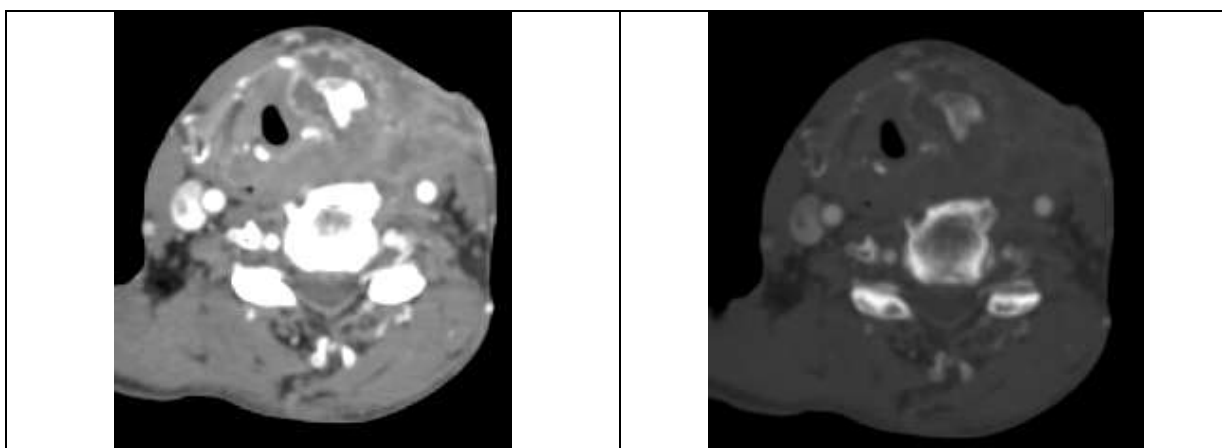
(a) and 7(b): Axial CECT and CT bone images at the level of thyroid cartilage in a case of Ca hypopharynx shows invasion and sclerosis of left thyroid cartilage with penetration into extralaryngeal space.
